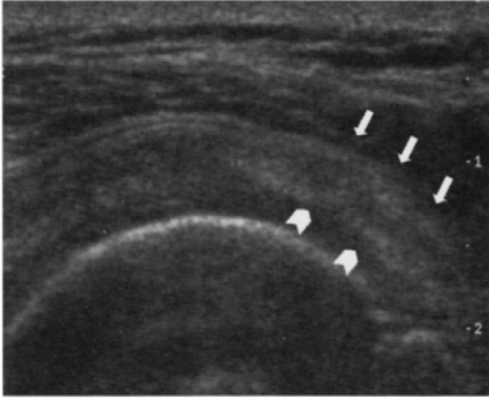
Transverse image of the supraspinatus tendon. Real Time Sono CT imaging is better showing the tendon structure focusing on the hypoechogenic area of tendon suffering on the front side of the tendon (arrows) mixed to the superficial area of abrasive injury (arrowheads).
